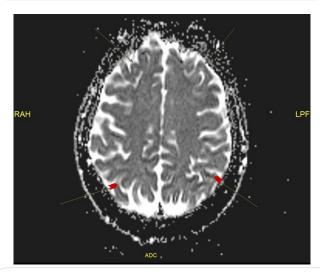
ADC image: Matched Gyral restricted diffusion with DWI
